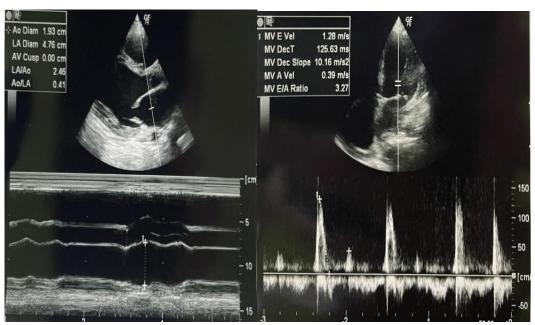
Low Ejection Fraction In PLAX View Of Echocardiography
